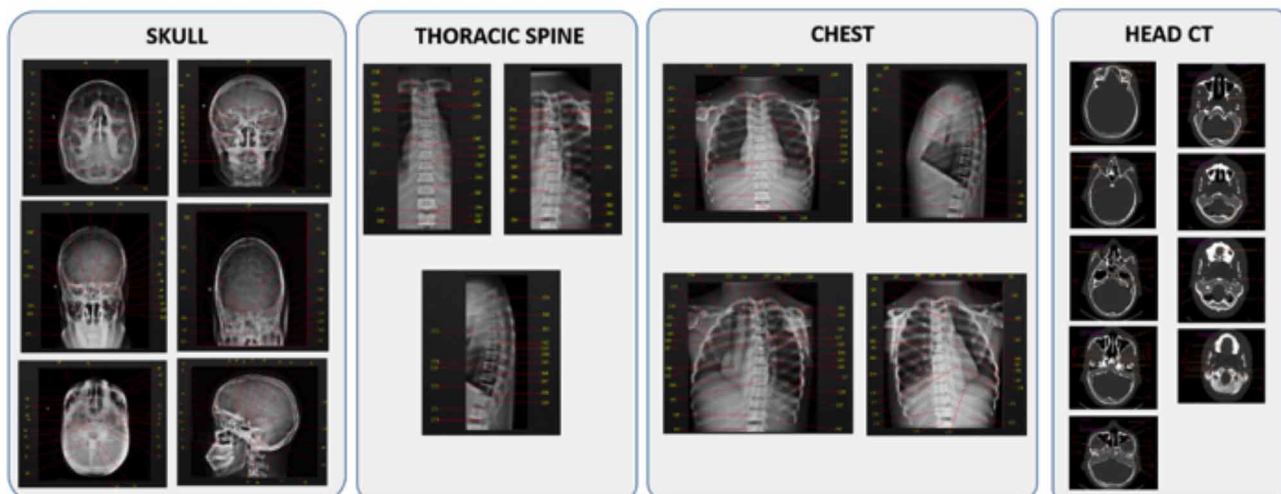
Radiographic and CT imaging.
